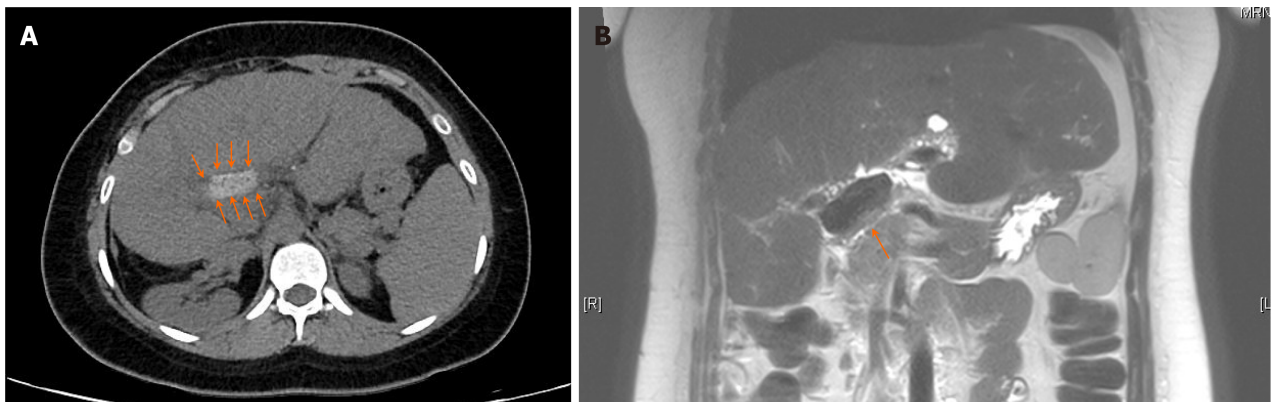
A stone at Kasai portoenterostomy sites in computed tomography and magnetic resonance imaging. A: The axial images of the abdominal computed tomography scan, taken in the local hospital before transfer, show a hyperdense lesion (arrows) at the hepatic hilum suggesting bile sludge or stone; B: The coronal image of the abdominal magnetic resonance imaging taken at our hospital after transfer shows a T2 low-signal intensity lesion (arrow) at the Kasai portoenterostomy site.
